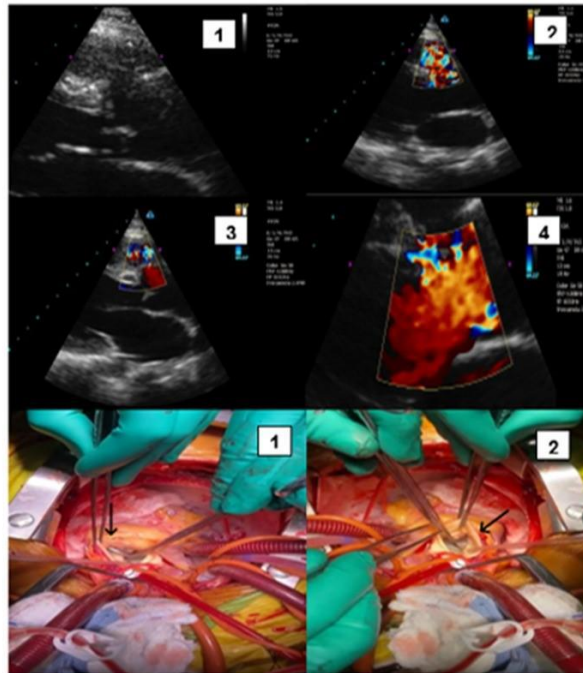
Echocardiographic images. 1. Continuity defect at the perimembranous SIV level. 2. color flow from the VI to the VD 3. Aneurysmal dilation of the right coronary sinus with rupture 4. Color flow from the aorta to the VD. Figure 2. Intraoperative images. 1. Ruptured sinus of Valsalva 2. CIV. Both draining to the VD
